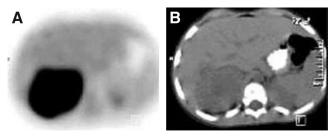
Transverse image from PET scan (A) and corresponding CT scan (B) of 3-y-old boy with neuroblastoma shows markedly increased uptake in right adrenal mass, the primary site of the patient's neuroblastoma.
